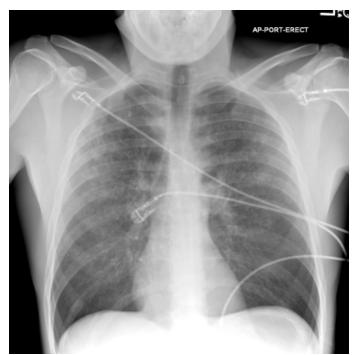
Chest radiography showing diffuse bilateral patchy infiltrates 60 minutes after propofol administration.
